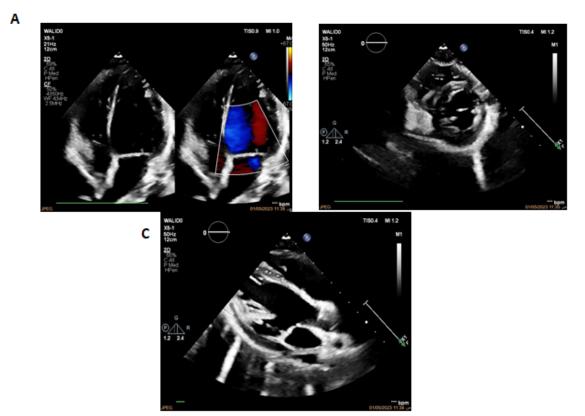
A: a 4-chamber 2-D echocardiogram with color Doppler view showed mild mitral regurgitation. B+C: short axis and long axis 2-D echocardiogram views showed mild left ventricular hypertrophy.
